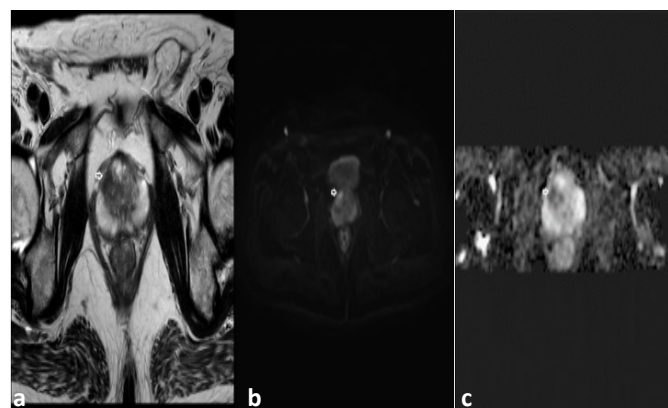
68-year-old patient with PSA 6.8 ng/ml, right transitional zone hypointense area on T2 (a), hyperintense on DWI (b), hypointense on ADC (c) PIRADS 5 lesion. Fusion biopsy result was compatible with Gleason score 3+4
